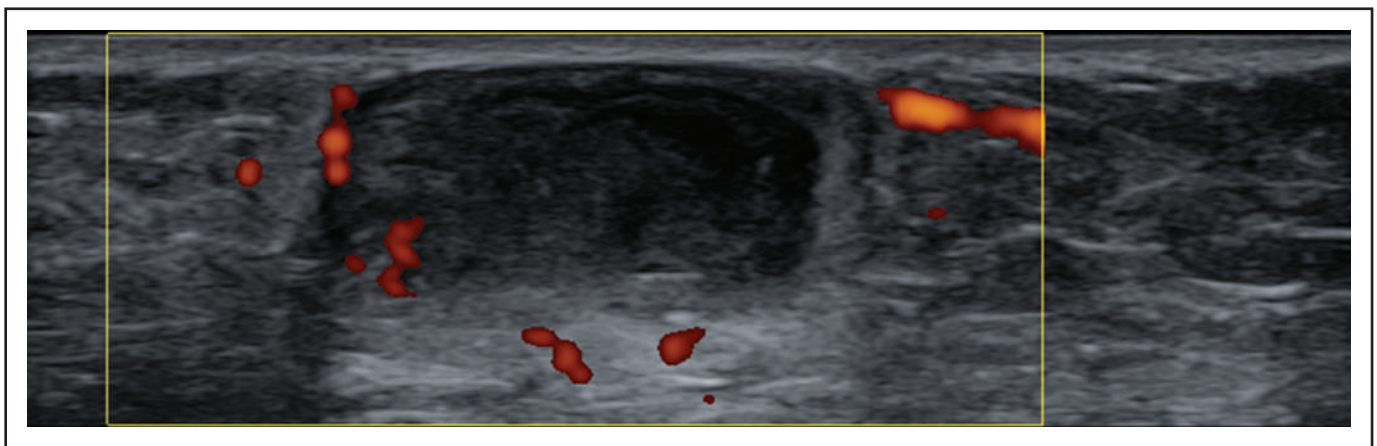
Blood flow in the hypoechoic structure revealed by Power Doppler. Only limited space has blood flow.
